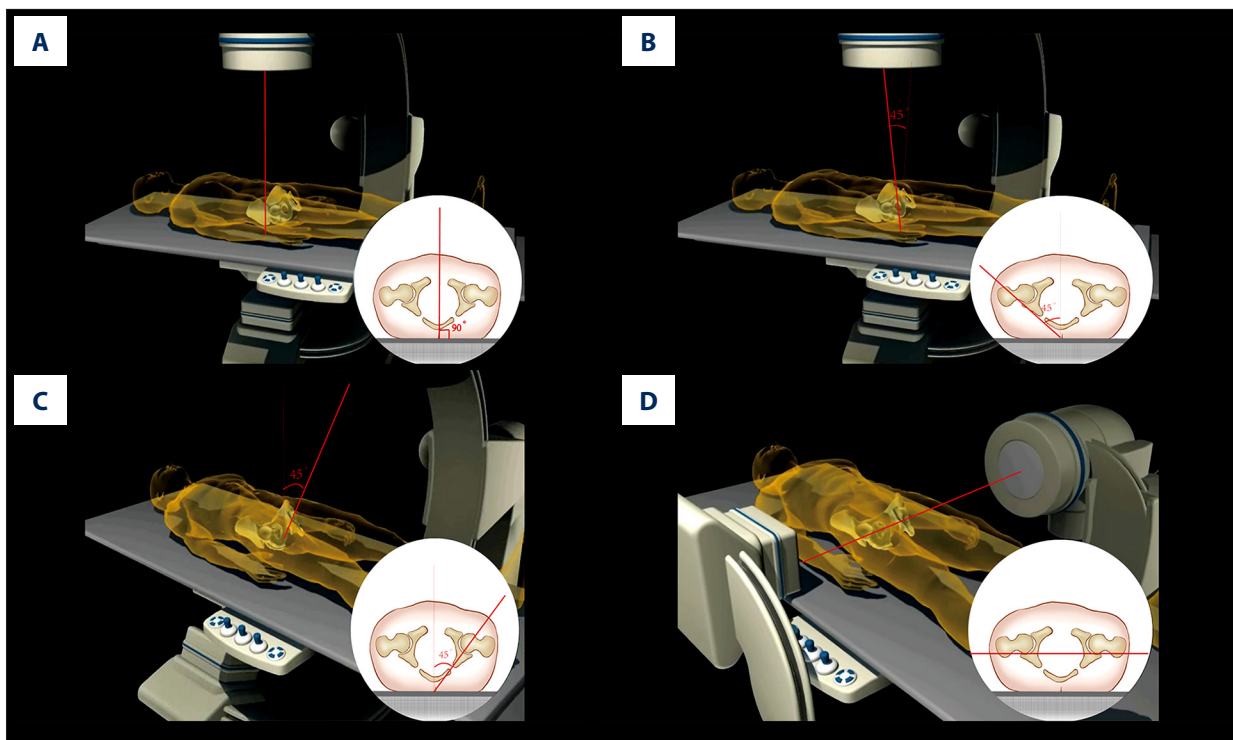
The fluoroscopic projection method of traditional and proposed radiographs used in pelvic model from a mobile fluoroscopy unit. (A) Anterior-posterior (AP) view. (B) Iliac obturator oblique view. (C) Obturator oblique view. (D) Lateral view of acetabular which is similar to lateral view of pelvic.
